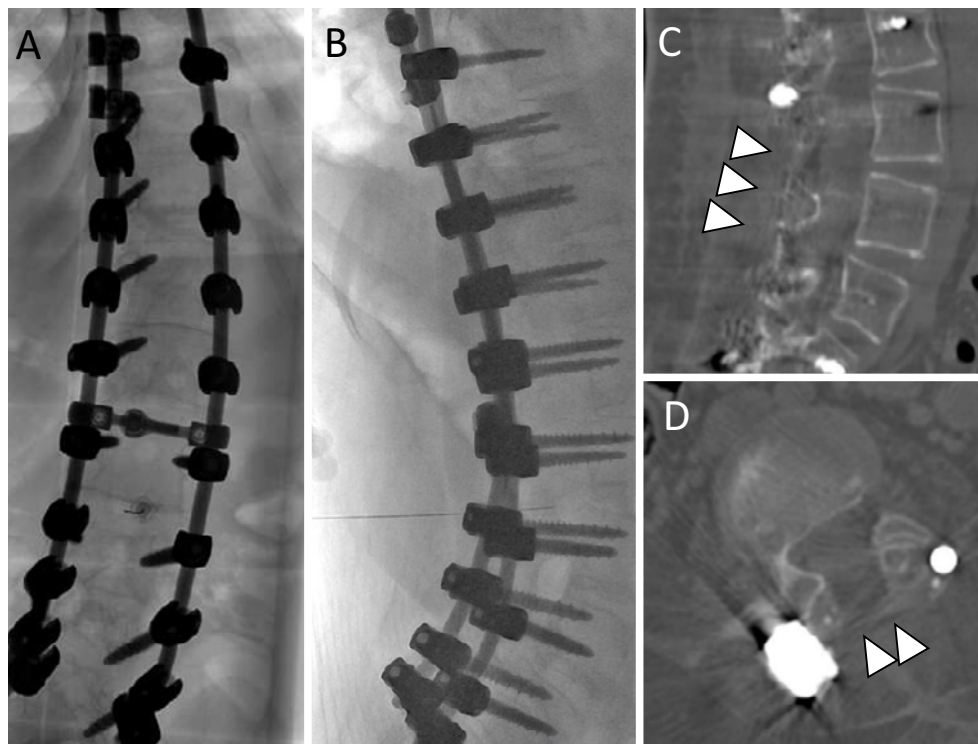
Fluoroscopic images and CT of the representative case during injection of Nusinersen. Frontal (A) and lateral (B) fluoroscopic views while the patient was prone and sagittal (C) and axial (D) CT views before Nusinersen injection. Intrathecal access was straightforward under fluoroscopic guidance.
